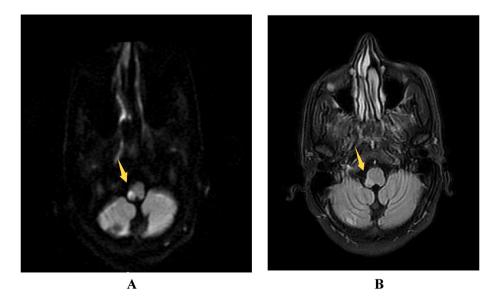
Axial diffusion-weighted MRI image showing the focal area of diffusion restriction in the dorsolateral medulla on the right side confirms acute infarction. Fig B: Axial T2-weighted and FLAIR MRI images showing the small focal area of hyperintensity involving the dorsolateral medulla on the right side suggestive of the infarct.
